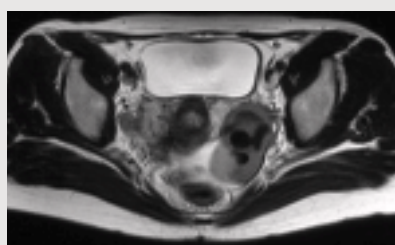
4 T2-weighted images
